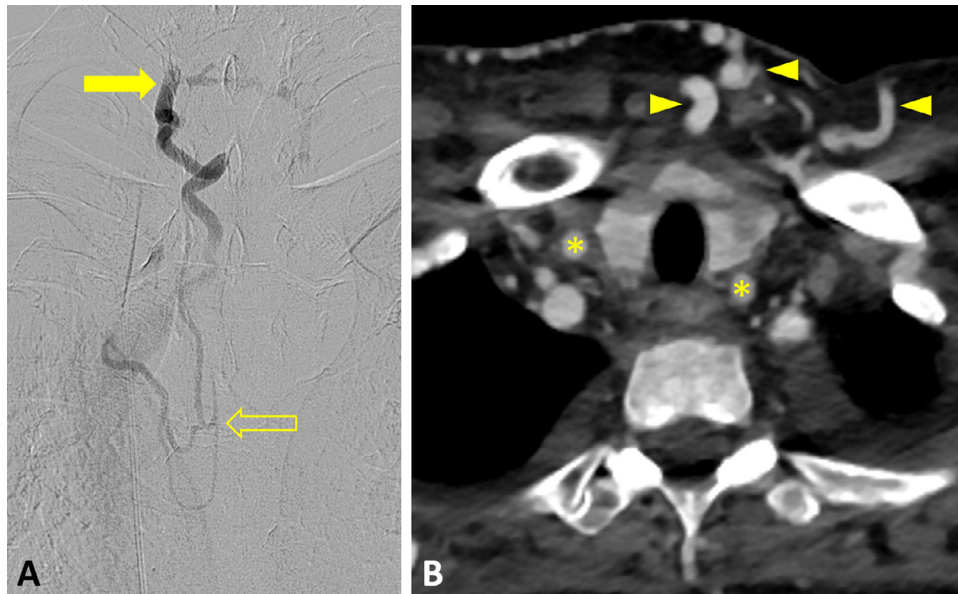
Chronic occlusion of the internal jugular veins. (A) Digital subtraction venogram of a right neck vein (arrow) near the anticipated location of the internal jugular vein demonstrates tortuous venous collateral vessels extending down to the mediastinum (open arrow). (B) Axial contrast-enhanced CT image of the upper chest demonstrates no identifiable internal jugular veins near the common carotid arteries (asterisks) bilaterally. Large anterior chest wall collateral vessels are noted (arrowheads). Bilateral subclavian veins were also occluded centrally (not shown)
